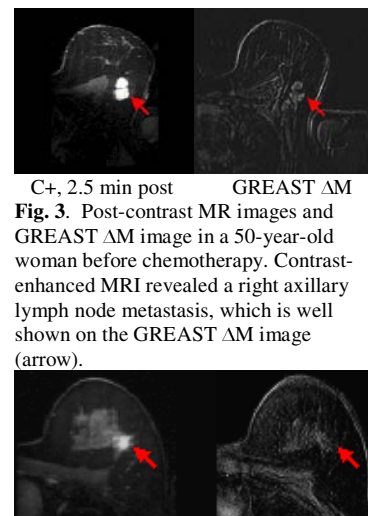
Post-contrast MR images and GREAST Δ M image in a 50-year-old woman before chemotherapy. Contrast-enhanced MRI revealed a right axillary lymph node metastasis, which is well shown on the GREAST Δ M image (arrow).
